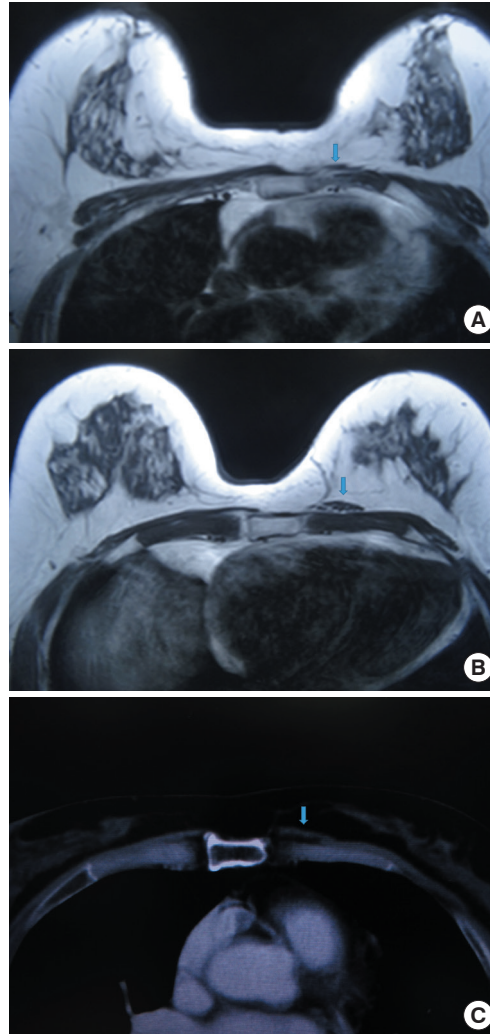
Imaging analysis of the sternalis muscle. (A) Image obtained 6.0 cm distal from the origin in T1-weighted magnetic resonance imaging. (B) Image obtained 9.0 cm distal from the origin in T1-weighted magnetic resonance imaging. (C) Image obtained 8.0 cm distal from the origin in computed tomography. The blue arrow indicates the sternalis muscle.
